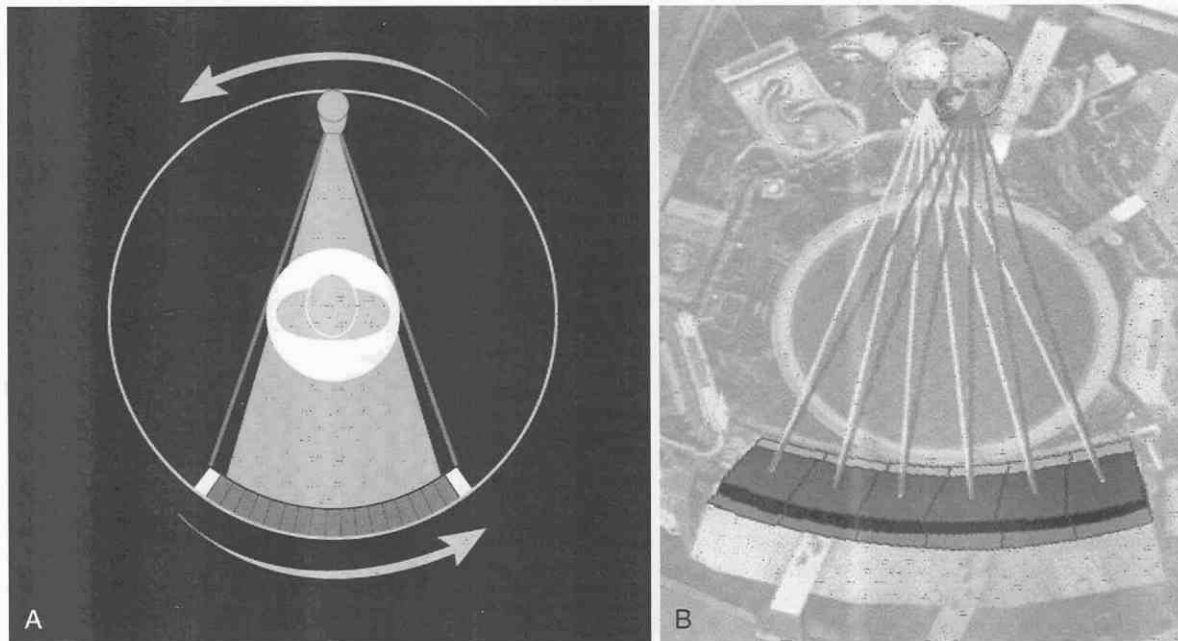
A, Third-generation rotate-only scanner geometry showing fixed relationship of x-ray tube and detectors. B, Dynamic focal spot technology (Marconi Medical Systems) effectively doubles the data sampling rate.
